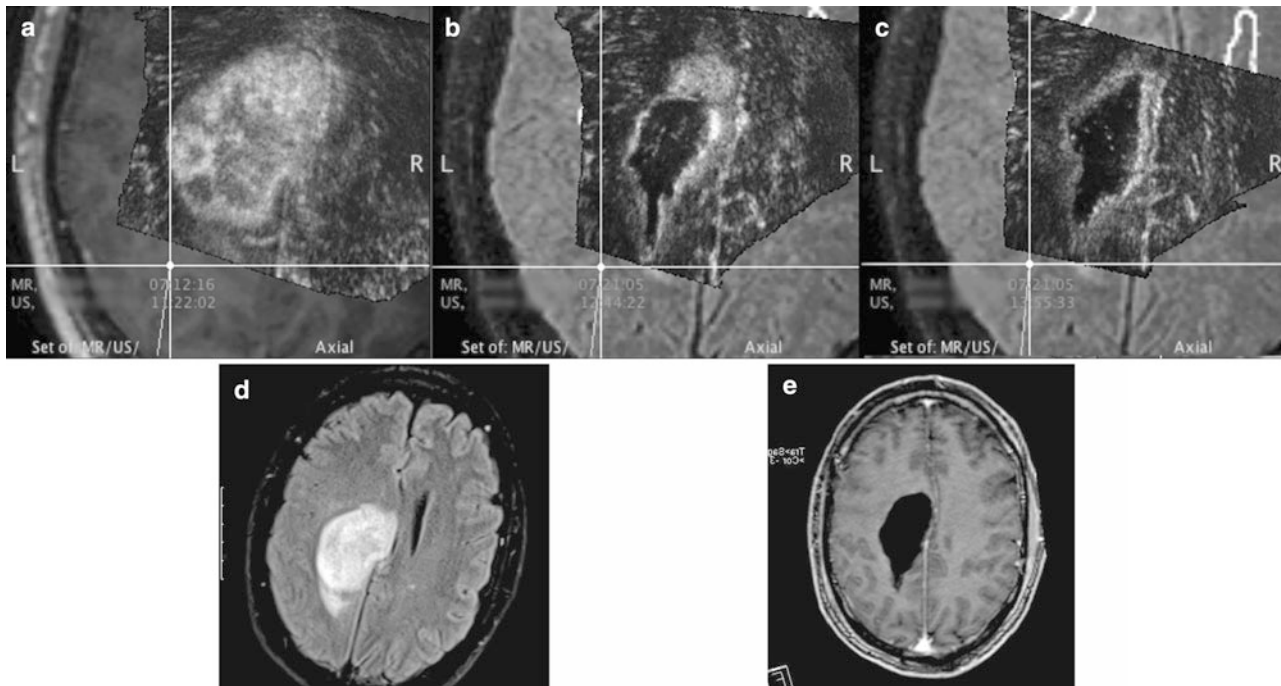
A high grade glioma. Intraoperative 3D US overlaid the 3D MRI volume, before start of resection (a), during resection (b) and at the end of resection (c). In the lower row is shown preoperative MRI (d) and postoperative MRI one day after operation (e)
